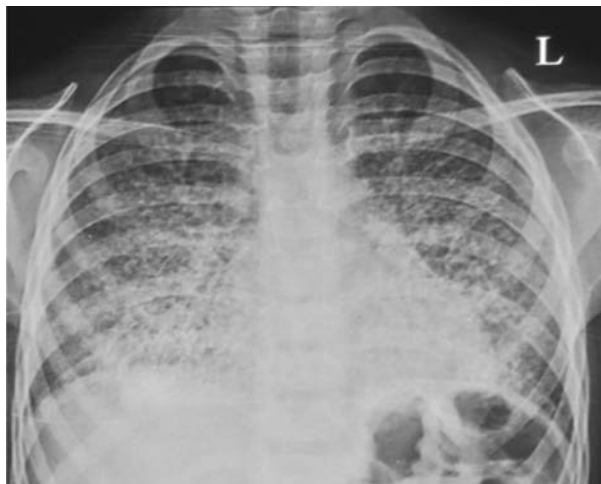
Chest radiograph showing diffuse reticulonodular opacities in both lung fields.
